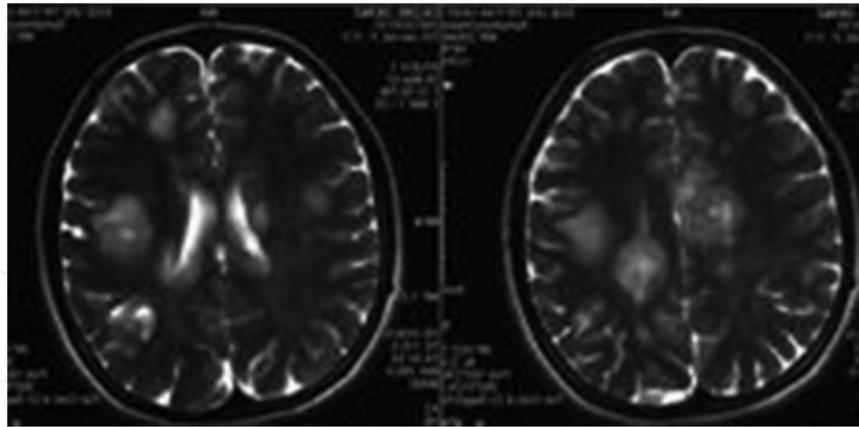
Large, hyperintense lesions on T2-weighted sequences.
